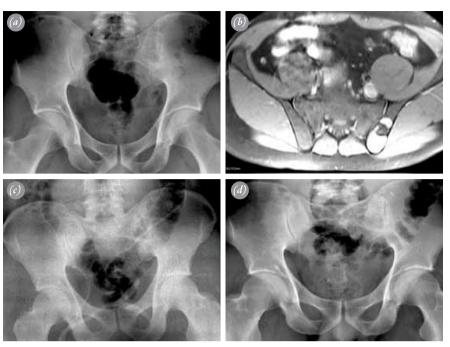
Thirty-five years old male admitted with pain in the left sacroiliac region. (a) Anteroposterior radiograph demonstrates a cystic bone lesion in the left iliac bone adjacent to the sacroiliac joint. (b) Axial magnetic resonance image of the lesion. (c) Intralesional curettage and bone grafting was performed. (d) After 31 months of follow-up, there was no radiological sign of recurrence on the anteroposterior radiograph of the pelvis.
